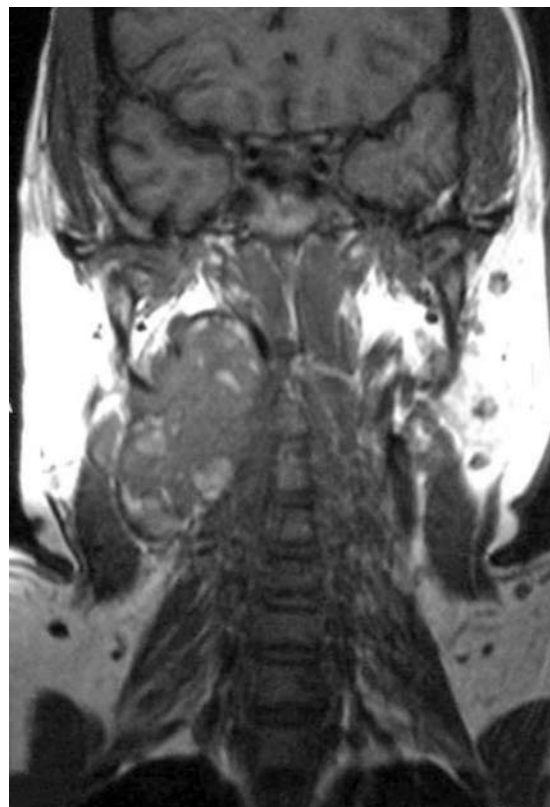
Coronal T1-W MR image shows the ectopic thyroid tissue in the right parapharyngeal space at the level of the bifurcation of the common carotid artery.
